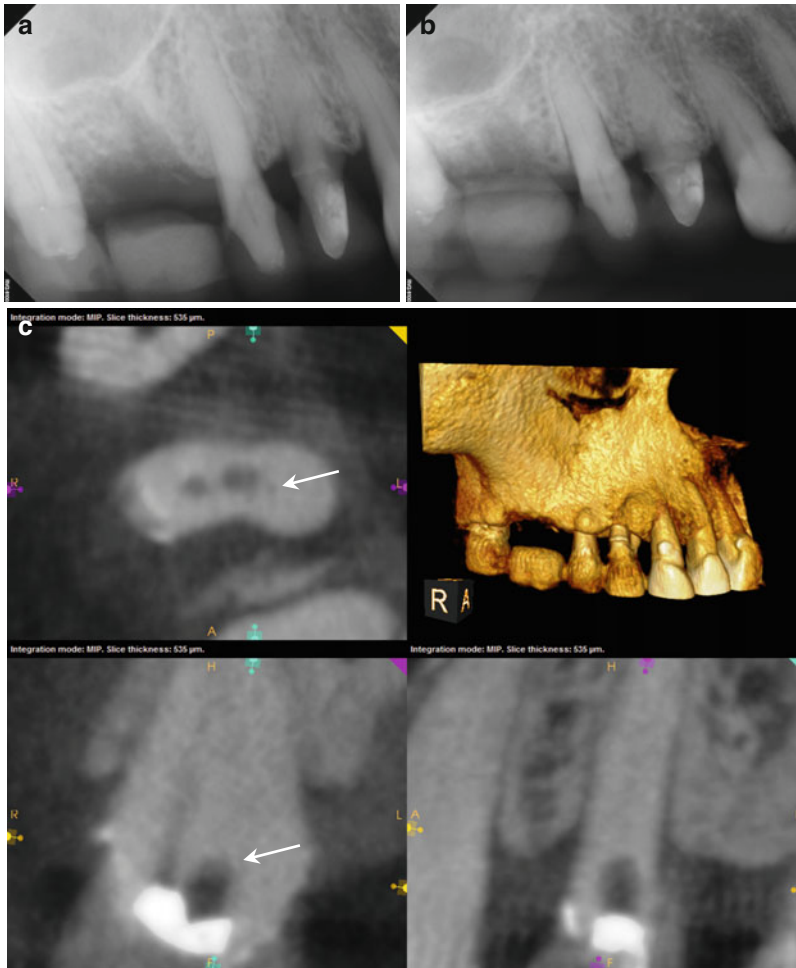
(a, b) Preoperative radiographs reveal dystrophic obliteration of the canal spaces in tooth #5. Access and instrumentation was performed on #4, but only the buccal canal in #5 could be located. (c) An intra-treatment CBCT disclosed the location of the palatal canal 1 mm palatal and mesial to the area of ultrasonic excavation (*white arrow*). Note the kidney bean shape and mesial invagination of the root form not appreciated on the 2-D image. (d) A colored axial section of the 3-D model demonstrates the instrumented canal diameters of #4 and the location of the palatal canal (*yellow arrow*) in #5. (e, f) Using a NiTi D11T spreader as an explorer, the palatal canal space is engaged and the orifice uncovered (*red arrow*). A small file will be inserted into the canal for verification and working length measurement. (g, h) Mid-obturation and final radiographs. Precise triangulation and accurate measurements guided the conservative excavation and location of this “calcified” canal in a critical abutment
